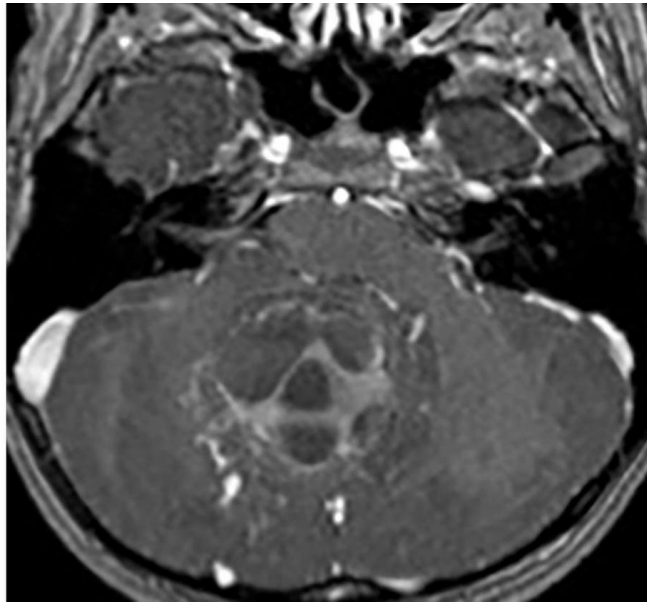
MR images demonstrate a large parenchymal lesion centered in the right cerebellar hemisphere causing significant adjacent mass effect and complete obstruction of the fourth ventricle. There is central reduced diffusivity (top left and top right) and a large amount of susceptibility (blooming) artifact on SWI (middle left) secondary to recent hemorrhage. (Middle Right) A FLAIR image demonstrates a moderate amount of hyperintense signal, which is typically seen only in lesions that have recently hemorrhaged or occasionally when the lesions are large and have a significant mass effect. (Bottom) Somewhat atypical is the degree of heterogeneous enhancement on postcontrast imaging.
